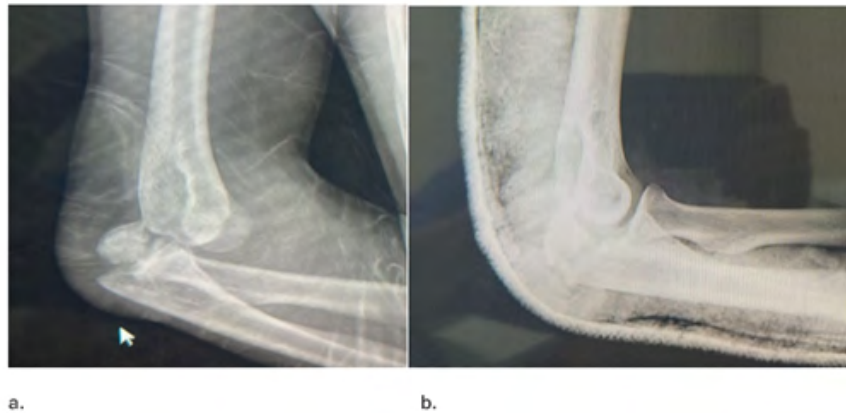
X-rays of the patient. a. fracture dislocation of right elbow. B. reduced elbow with posterior splint
